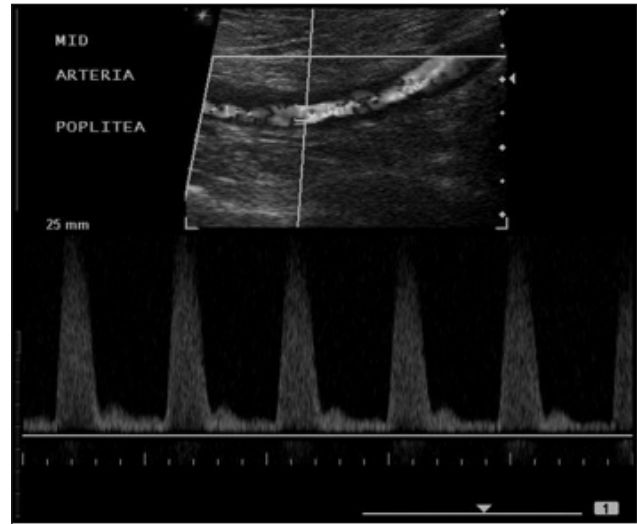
Transversal view of duplex ultrasound scanning at one-year follow-up showing good flow through the popliteal artery and triphasic waveform.
